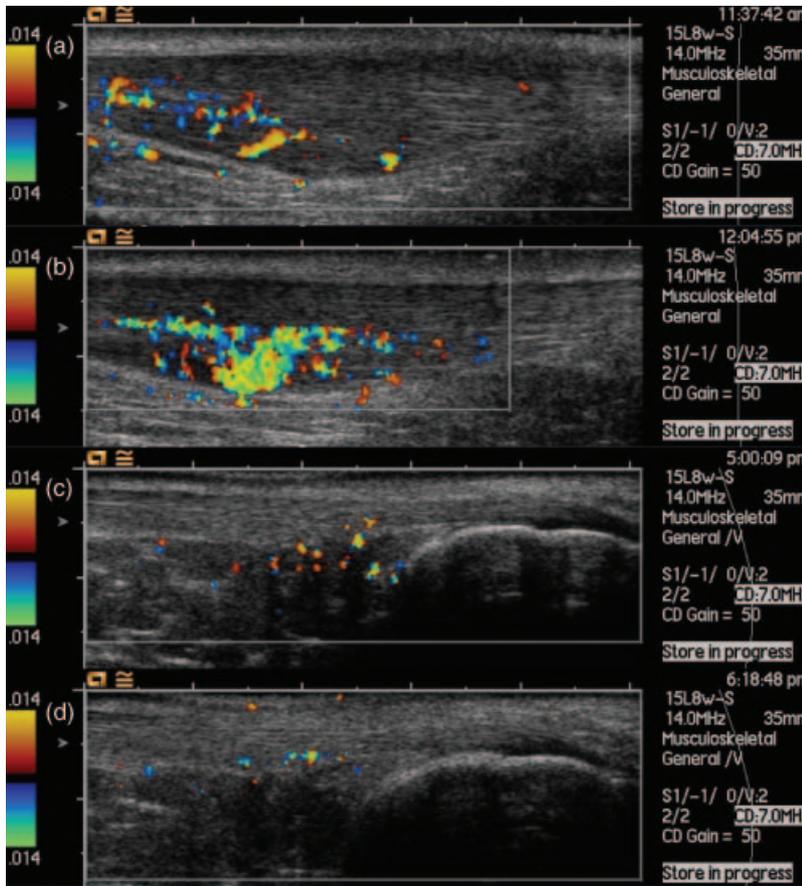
Intratendinous Doppler activity before and after exercise. (a)Before and (b)After eccentric exercise in a patient with chronic Achilles tendinosis. The scan planes are not identical but represent the scan plane with the maximum Doppler activity. Proximal is oriented left and posterior is oriented up. There is clearly more intratendinous Doppler activity in (b). The sharp posterior demarcation of the color pixels is because the Doppler activity is in the soleus part of the tendon. (c)Before and (d)after a 5 km run in a normal subject. Proximal is oriented left and posterior is oriented up. Before the run there is a slight intratendinous Doppler activity – only the two most posterior color foci are with absolute certainty inside the tendon. Most of the Doppler activity is anterior to the tendon. After the run, there is more intratendinous flow. Most of the Doppler activity in (d) is inside the tendon. *Comment:* Please notice that the images were recorded with focus on the Doppler findings, and image plane and insonation angle were not optimized for gray-scale evaluation.
